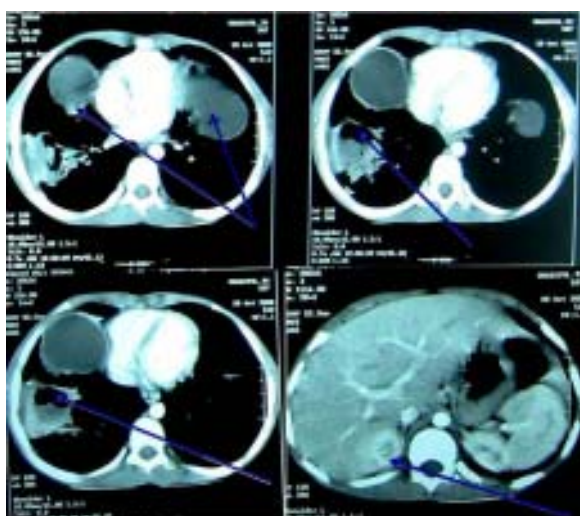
CT Scan of Chest: showed large irregular enhancing mass lesion having air fluid level in right lower zone, well defined cystic lesions in both lungs, no calcification was seen.
